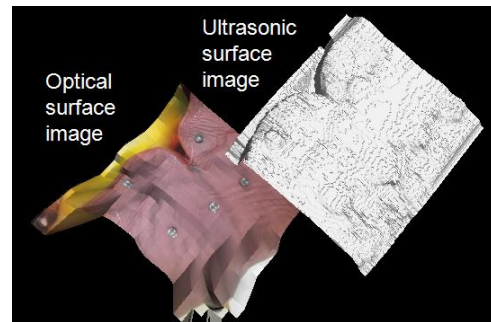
3-D surface images of optical and ultrasonic before registration
